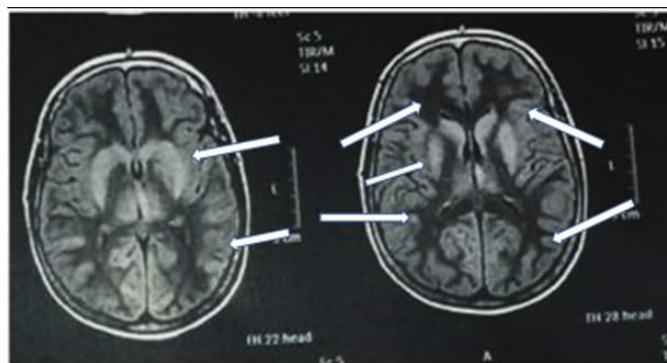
MRI brain shows bilateral symmetric involvement of the thalamus and lentiform nucleus with the hyper intensities (white arrows) in flair axial images suggesting sub-cortical white matter toxic demyelination
